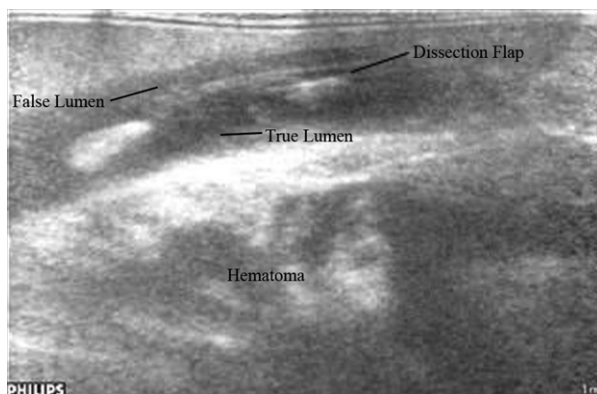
Epiaortic sonography visualizes the intramural hematoma and mid-LAD dissection.
